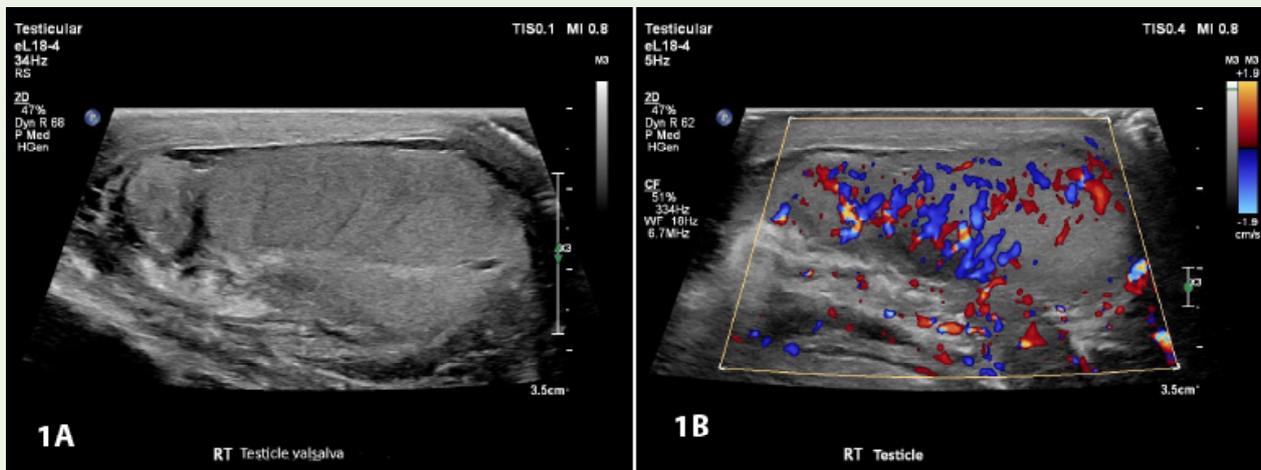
Epididymo-orchitis in a 24-year-old man with groin pain. (A, B) Sagittal gray-scale (A) and color Doppler (B) US images show a markedly inflamed thickened scrotal wall and substantial hyperemia is evident on color Doppler US image (in B) indicative of orchitis.
